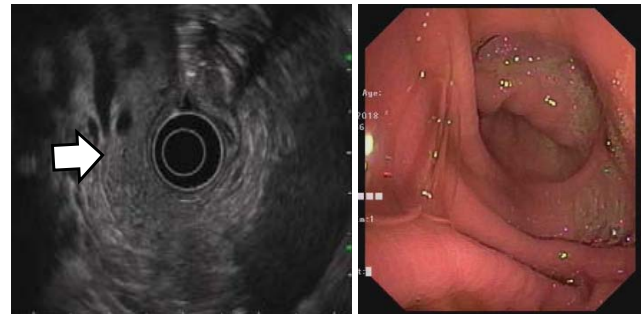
Stenosis of common bile duct (CBD) by endoscopy ultra sonography/EUS (left) and sideview scope visualization (right)
